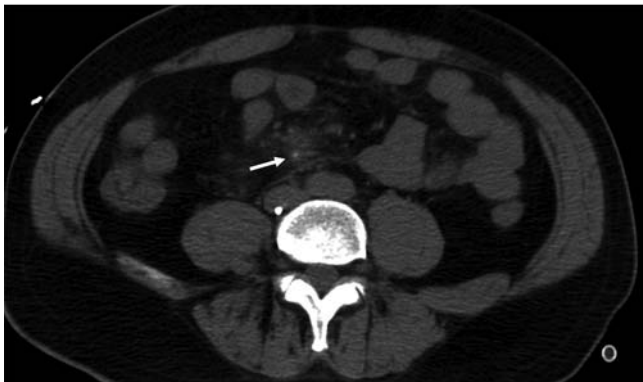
Unenhanced abdominal CT demonstrated a hyperdense dot (arrow) with surrounding "dirty" fat.
